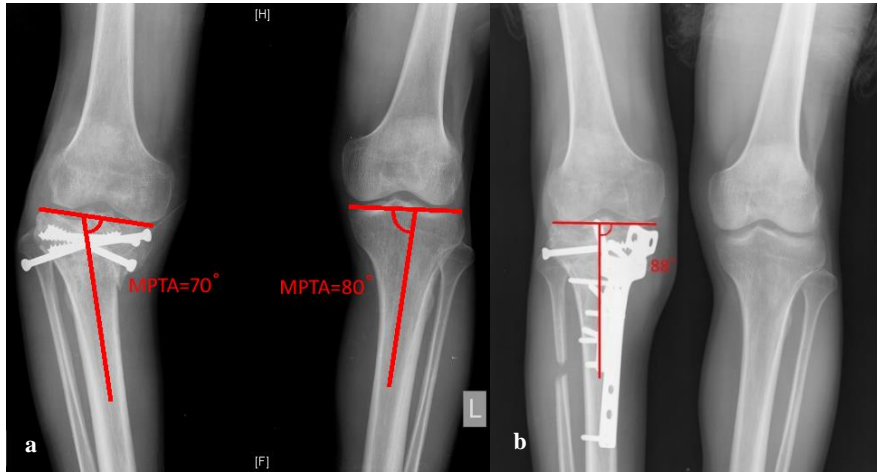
(a) Pre-op radiograph with deformity measured, (b) post-op radiograph showing correction.
